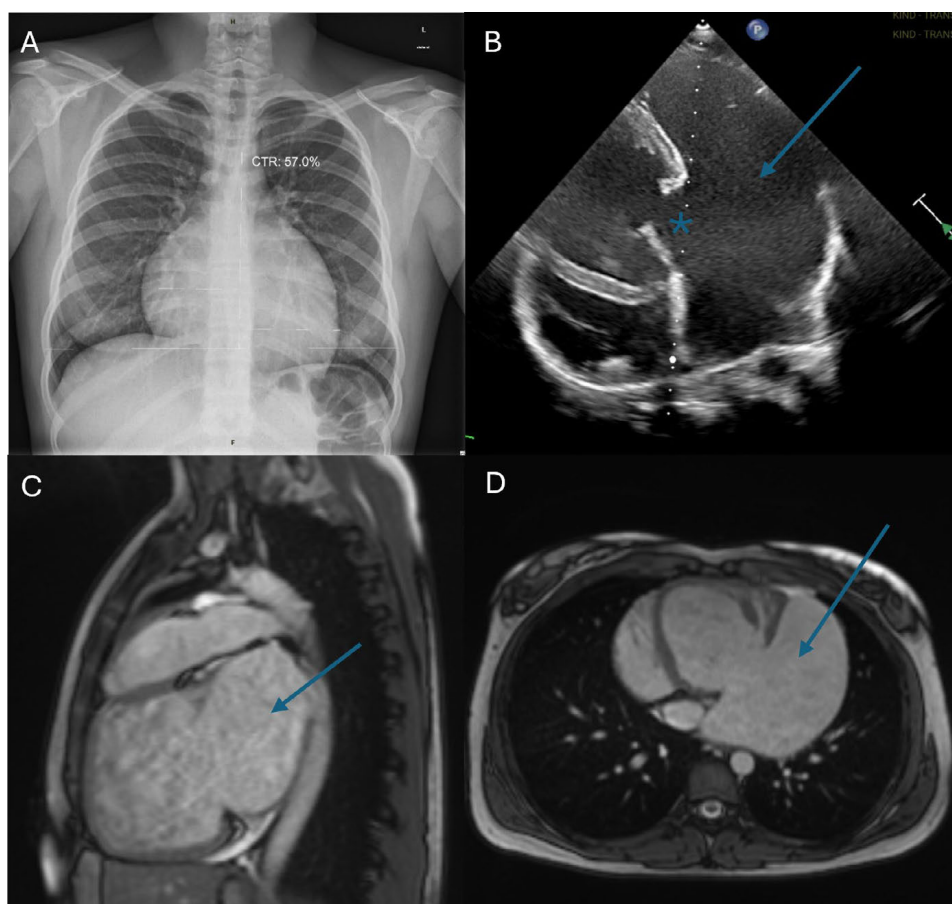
Preoperative diagnostic: (A) chest x-ray p.a. view, (B) transthoracic echocardiographic apical four-chamber view with arrow to left atrium and asterisk at the mitral valve, (C) MRI sagittal view with arrow to left atrium, (D) MRI axial view with arrow to left atrium.
